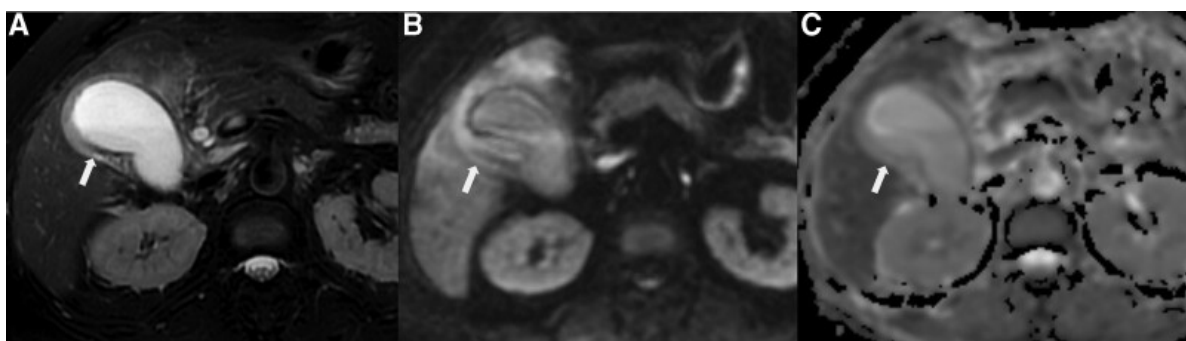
(a-c): Acute-on-chronic cholecystitis in a 69-year-old female, (a) T2WI fat-sat shows diffuse gallbladder wall thickening with layered appearance; inner wall hypointensity and outer wall hyperintensity are seen, without papillary change, (b) DWI demonstrates diffuse hyperintensity with layered appearance, (c) ADC map clearly depicts the layered hypointense pattern
